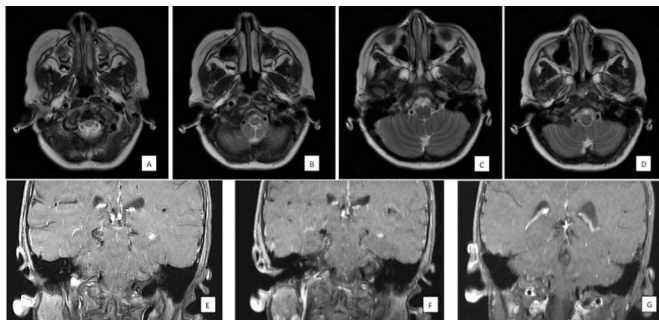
Axial T2-weighted images on MRI (A–D) and coronal T1-weighted images with contrast enhancement (E–G), showing no residual lesion.
